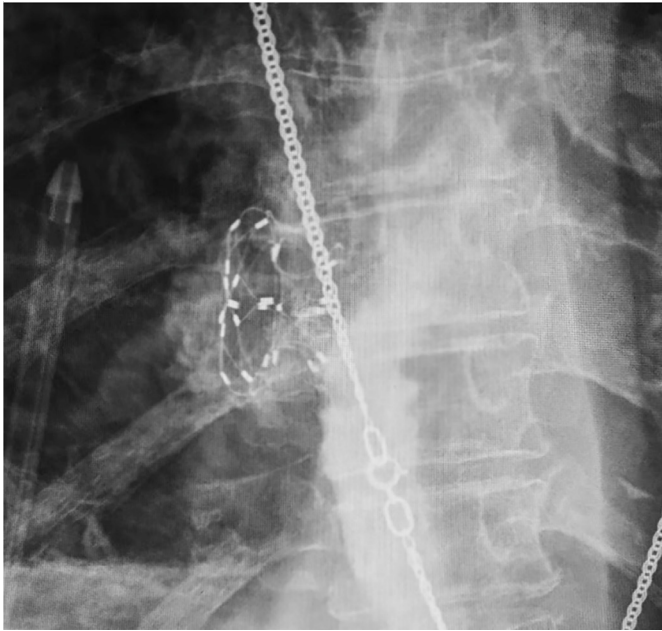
X-ray taken the day after occluder placement.
